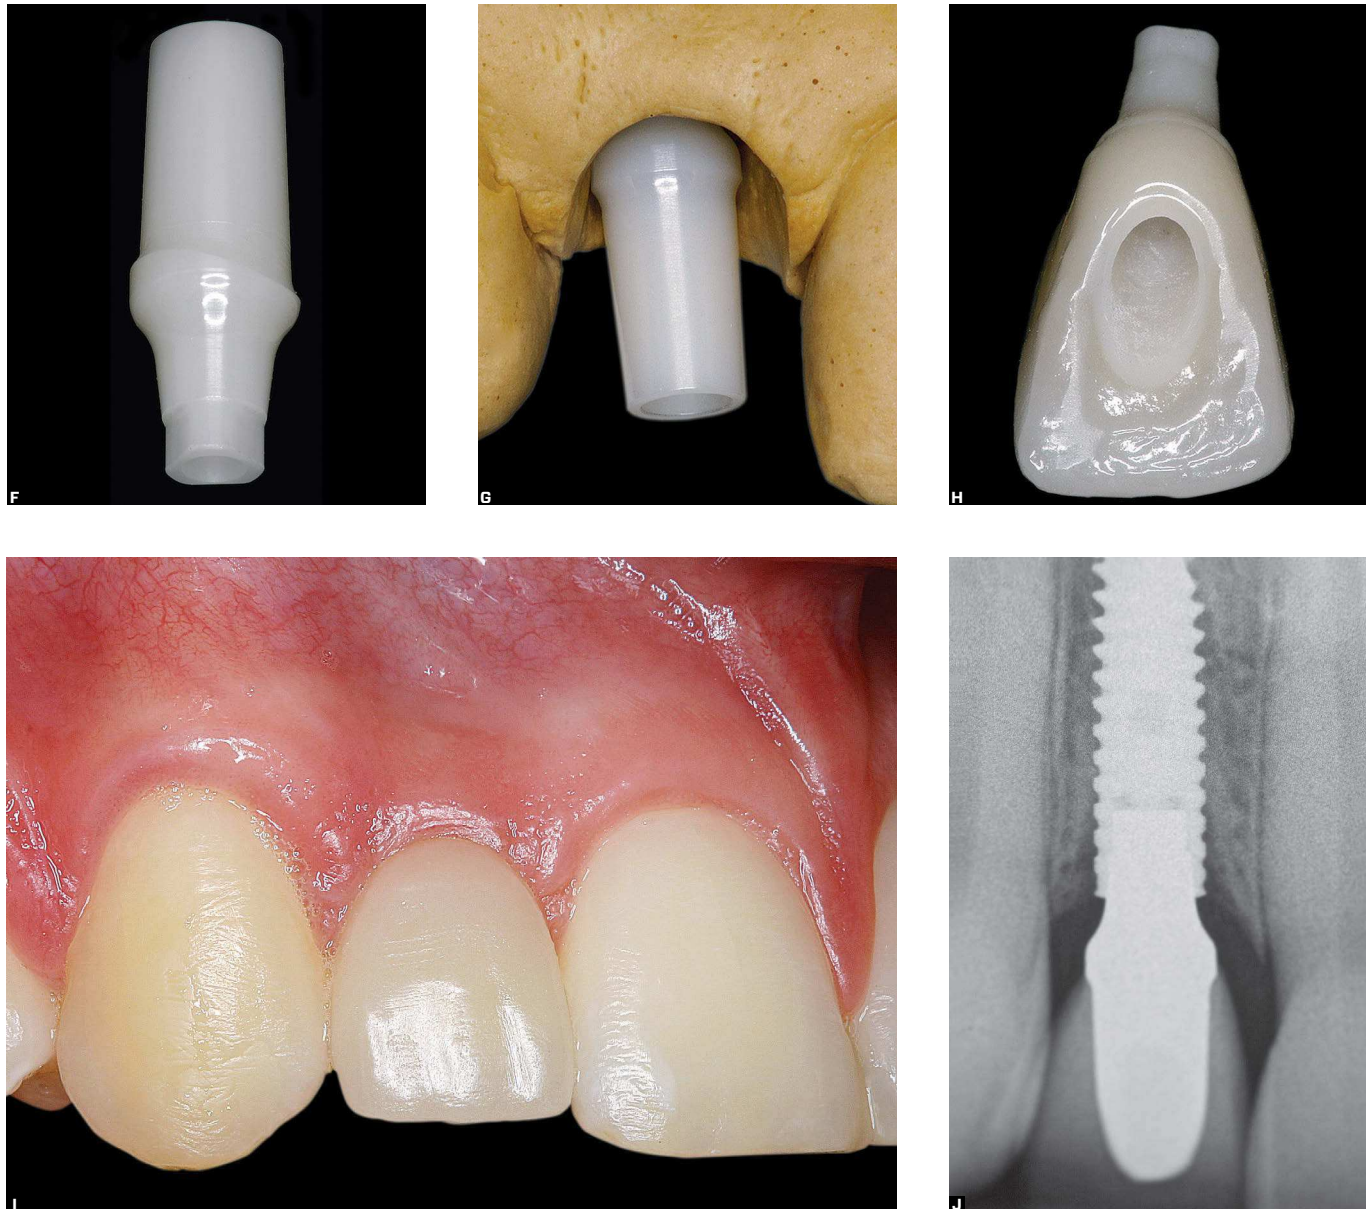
F) Zirconium abutment. Abutment adapted to cast (G) and covered with porcelain (H). I) Ceramic crown screwed to implant; satisfactory transition from surrounding gingiva. J) Radiograph shows satisfactory progression of peri-cervical bone and prosthetic abutment with biological concave profile. Clinical and radiographic control at 2 years.
